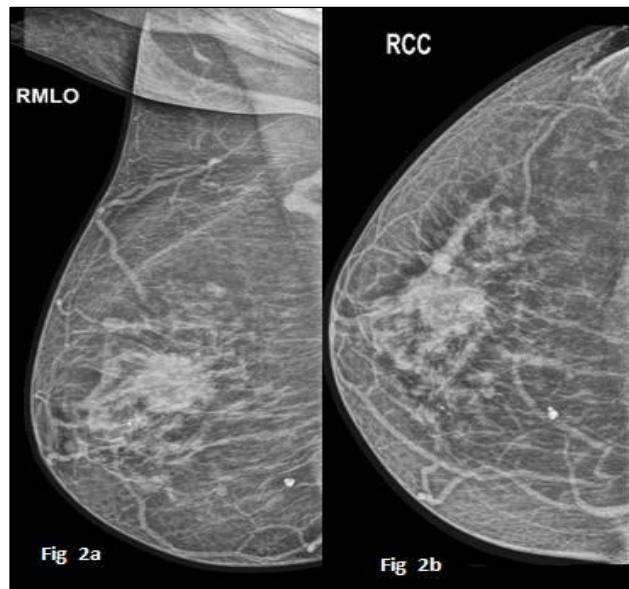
X-ray mammogram showing irregular ill-defined not circumscribed microlobulated and speculated hyper dense mass in retroareolar region in CC (Figure 2a) and RMLO views (Figure 2b).
